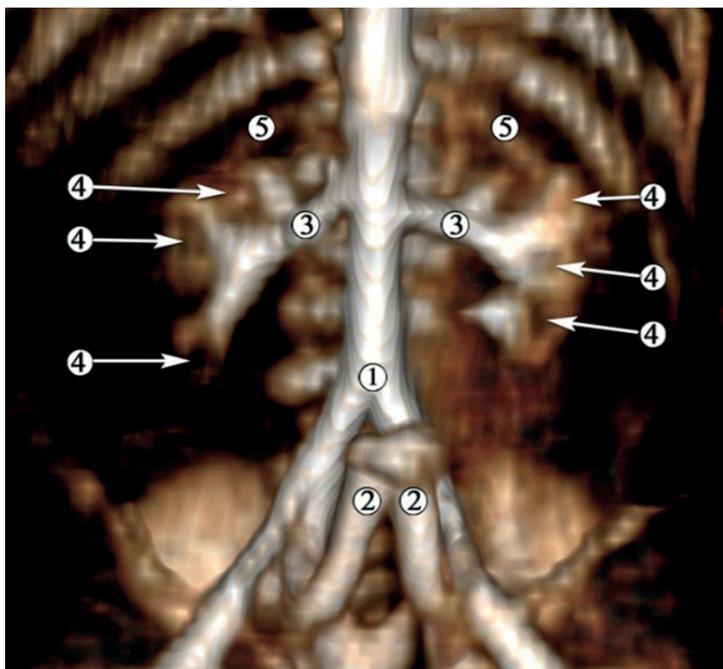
CT of a 5-month-old human fetus (155.0 mm PCL). Injection of the arterial system with a composition of red lead. Anterior projection. 3x: 1 – bifurcation of the aorta; 2 – umbilical arteries; 3 – renal arteries; 4 – contours of the minor renal calices; 5 – XII rib.
